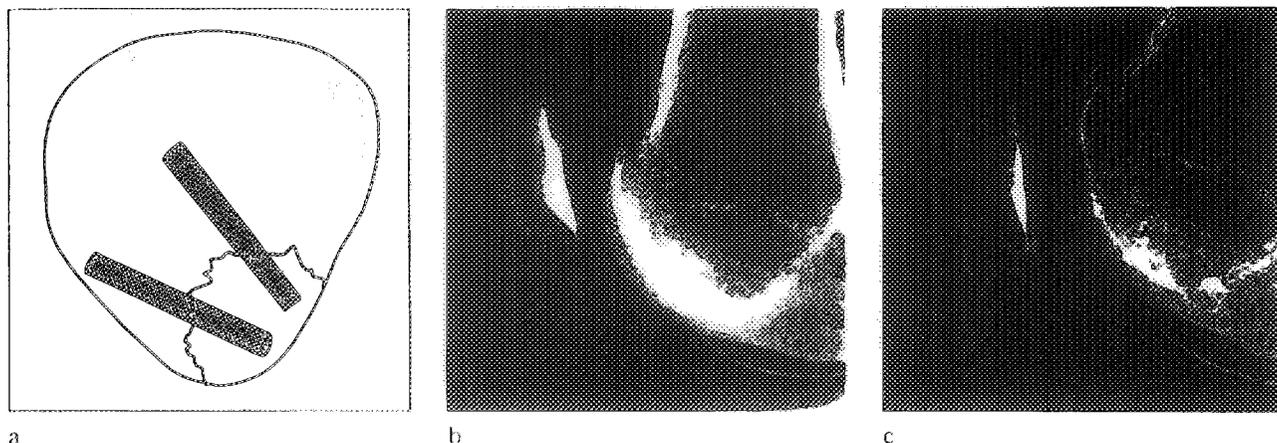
Fixation of fracture of the patella (a). Radiograph of a marginal fracture of the patella seen on admission (b) and six months after fixation with two 2 by 30 mm BIOFIX®-rods (c)
